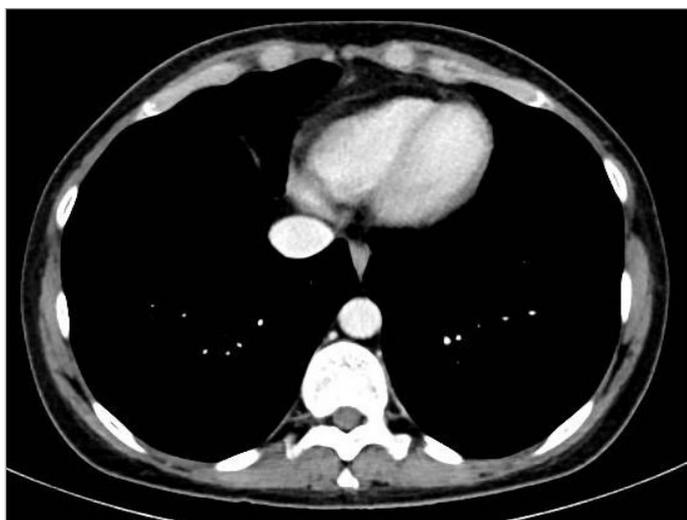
Chest CT shows resolution of the lesion.
